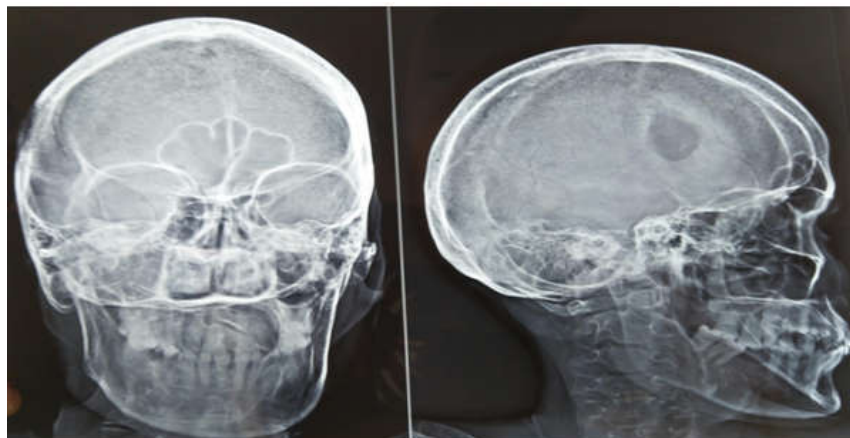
A plain radiograph of skull showing skull bone erosion of outer skull table with impending erosion of inner table.
